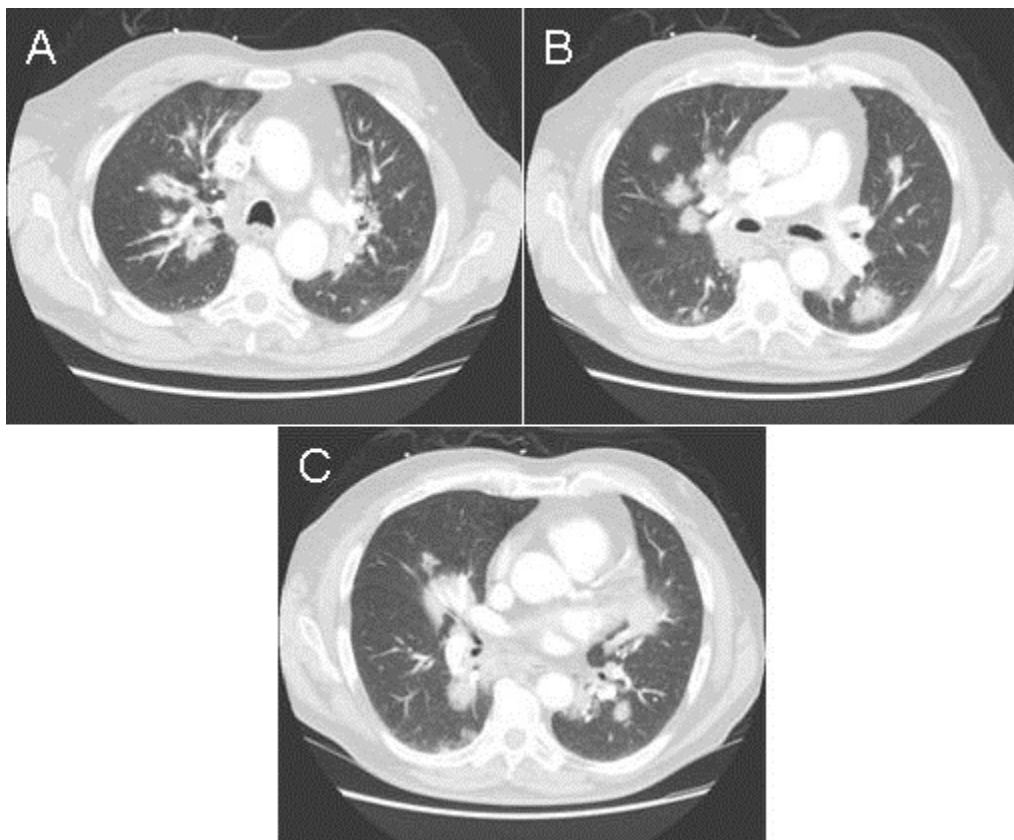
Representative images from the thoracic CT scan in lung windows.
